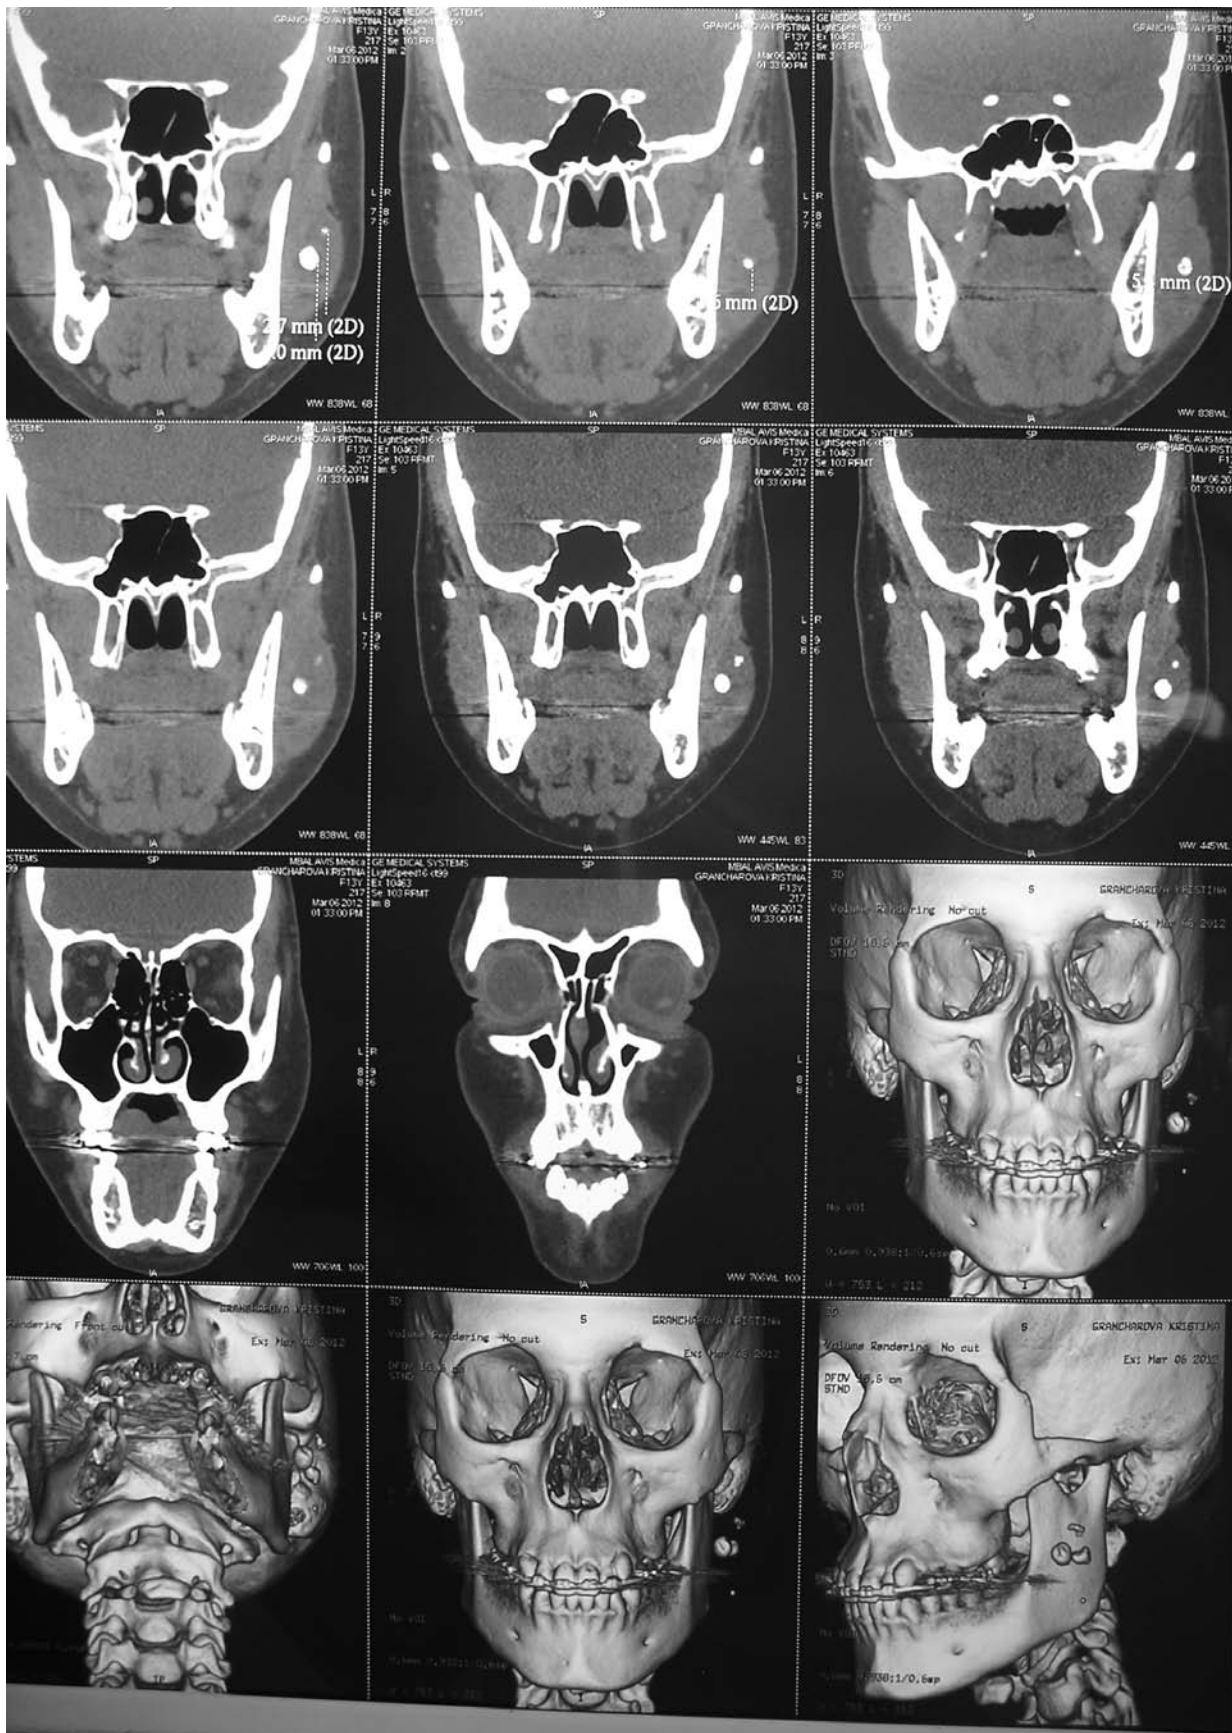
CT image of echinococcus calcified cysts in left masseter muscle
